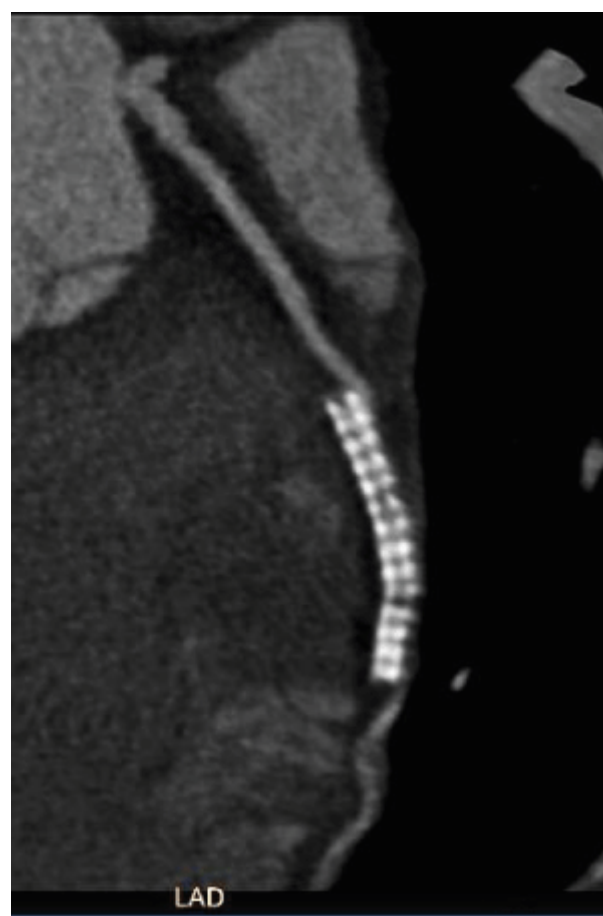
CT angiography was performed which demonstrated two sequential stents in the LAD (left anterior descending artery) in which in stent restenosis (ISR) was unable to be excluded. Furthermore, it appeared that the proximal end of the first stent was outside the vessel lumen.
